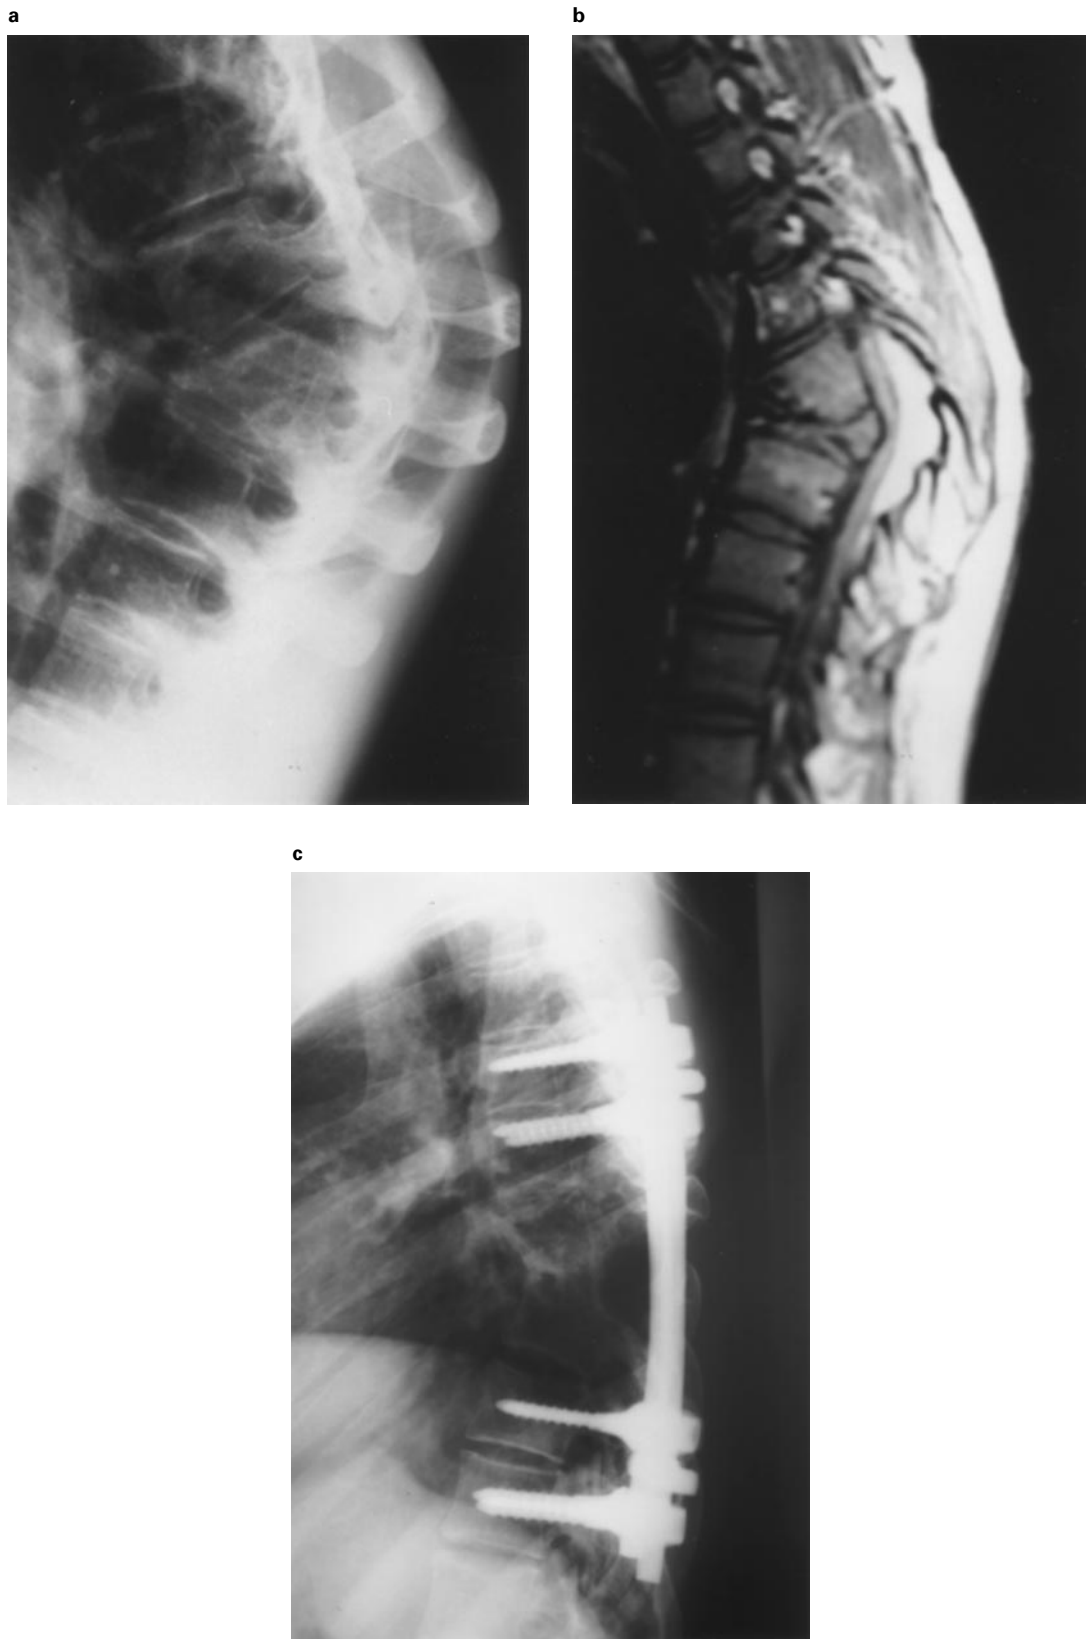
(a) Lateral tomogram, showing dysplasia of T7 and T8 vertebrae and angular kyphosis of 61°. (b) MR image, showing severe tethering of the spinal cord. (c) Plain lateral radiograph, showing the correction of kyphosis to 26° postoperatively
